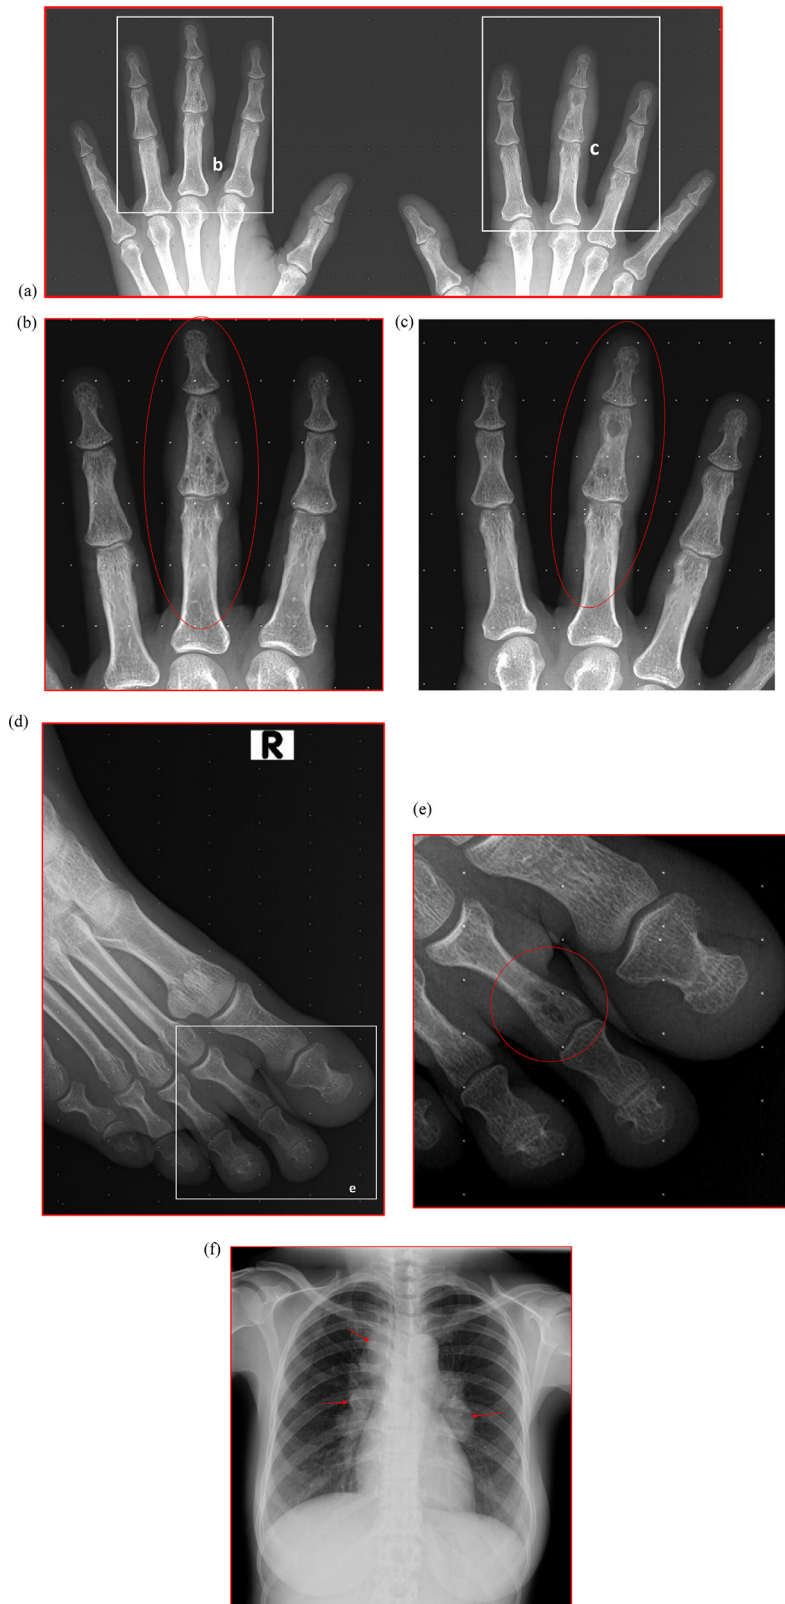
Bilateral hand, right foot, and chest radiograph—lace-like lytic lesion seen in the middle phalanx of bilateral middle finger and distal part of middle phalanx of right second toe. (Note the oval circle with red color outline in b, c and e). The middle finger of bilateral hands has also soft tissue swelling suggesting dactylitis (compare middle finger with un-affected index and ring finger for better appreciation of soft tissue swelling). Right paratracheal and bilateral hilar enlarged lymphadenopathies (red arrows) seen forming typical “123 Sign” used to describe sarcoid mediastinal lymphadenopathy.
